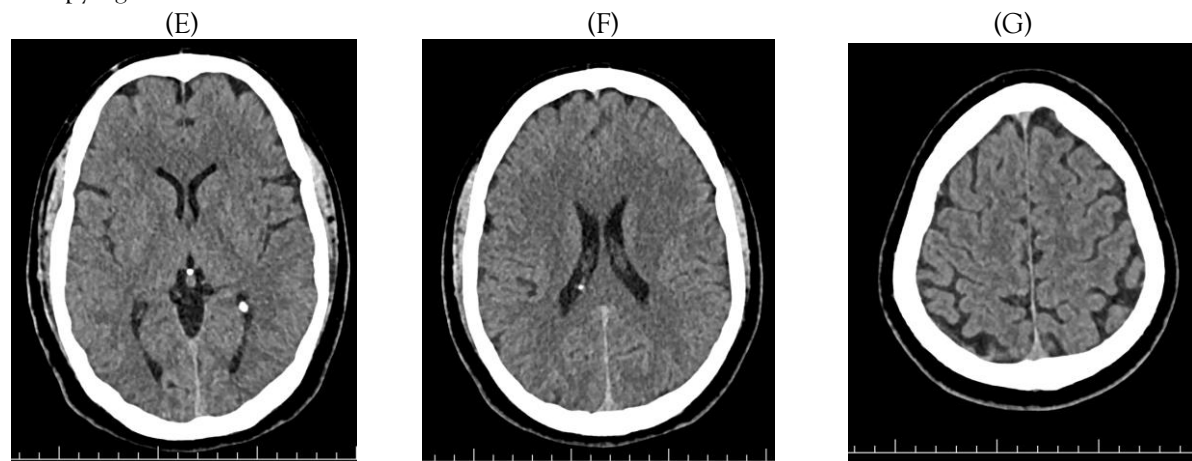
E, F & G- Shows Computed tomography of brain- plain- Normal study.
